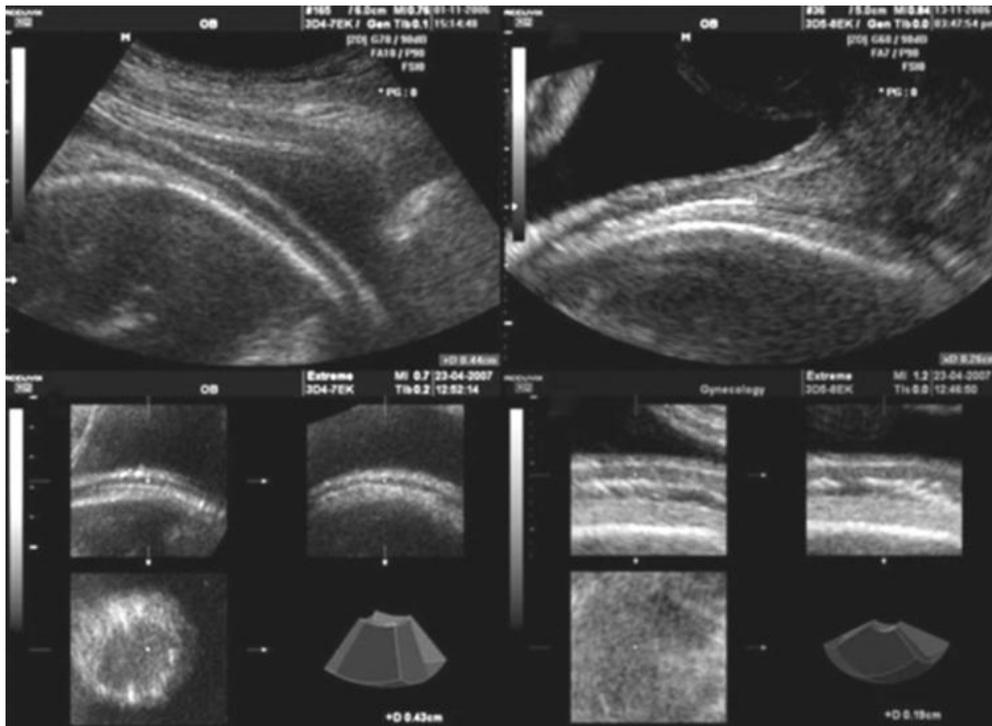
Measurement of the entire thickness of the lower uterine segment (LUS) by transabdominal two-dimensional (a) and three-dimensional (c) ultrasound and of the muscular layer of the LUS by transvaginal two-dimensional (b) and three-dimensional (d) ultrasound.
